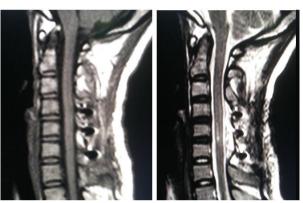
7 T1, T2 MR images post-operation
